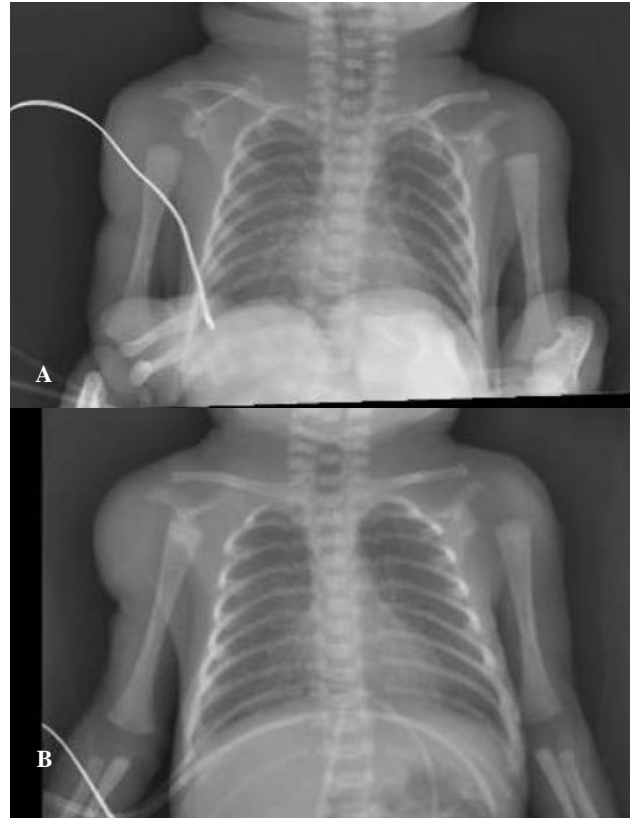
(A and B): Control x-ray after immobilization with clothes.
